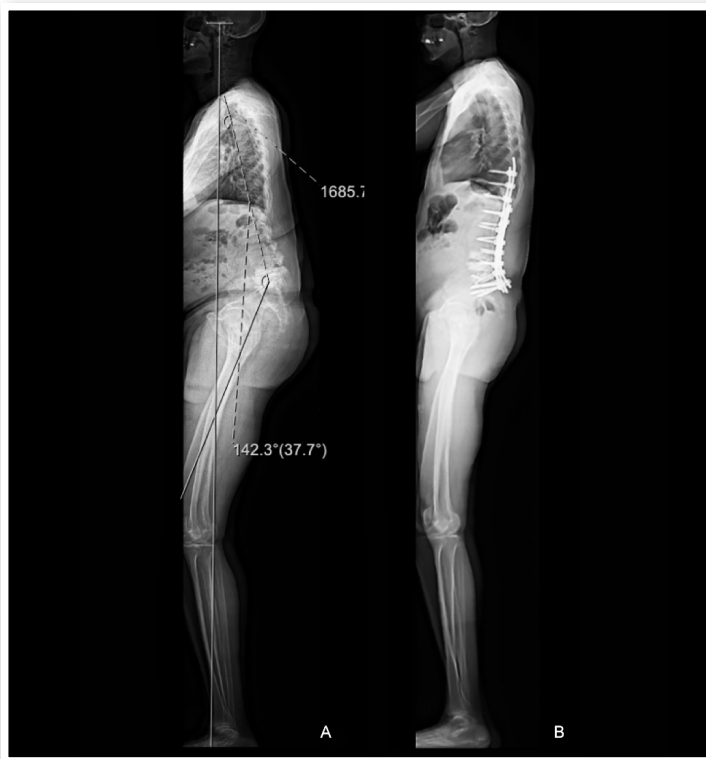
Comparison between pre-operative and three month post-operative full length standing x-ray showing the difference in posture, and the disappearance of compensatory mechanisms.
